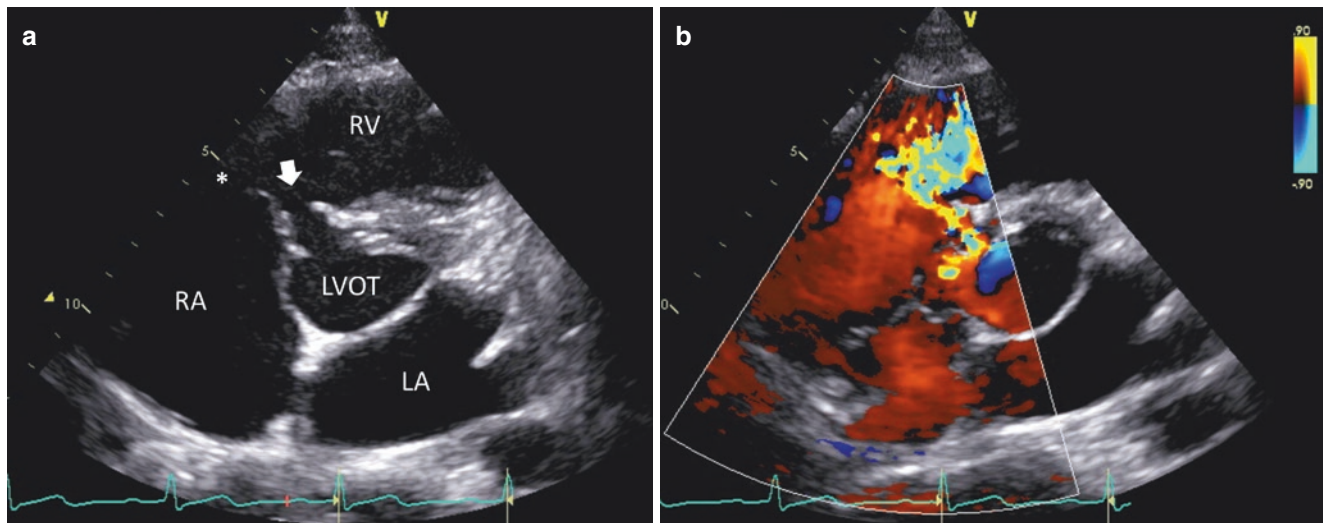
Membranous ventricular septal defect. (a) Parasternal short-axis view demonstrating a membranous ventricular septal defect (arrow). Due to the proximity of the tricuspid valve (asterisk), this type of defect is also described as sub-tricuspid. (b) Color-flow Doppler
